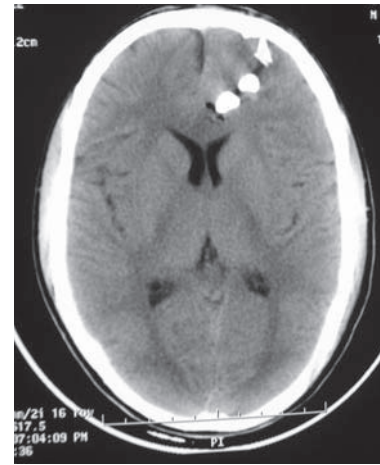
Preop. CT Head showing three globular hyper dense objects in left frontal region
